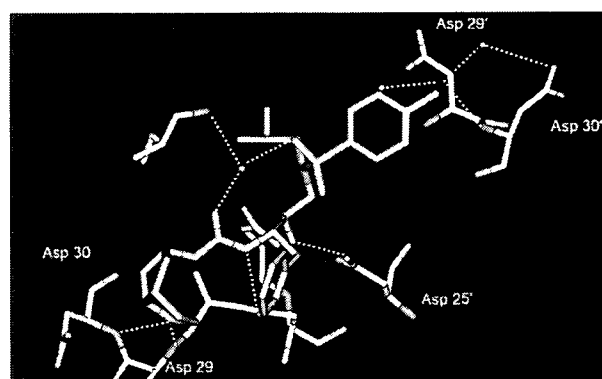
Inhibitor 23-bound X-ray structure of HIV-1 protease.
